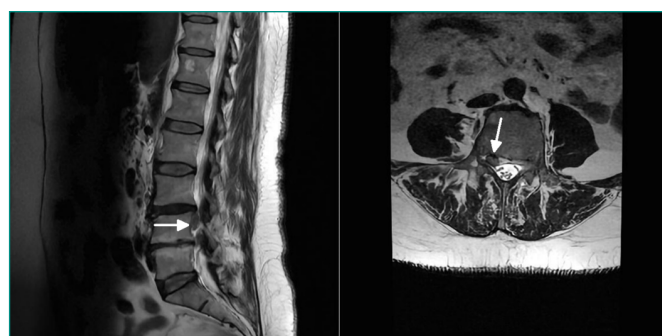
Microphotographs show T2-weighted MR axial images of a patient with right-weighted disc herniation in the L3-4 level.
